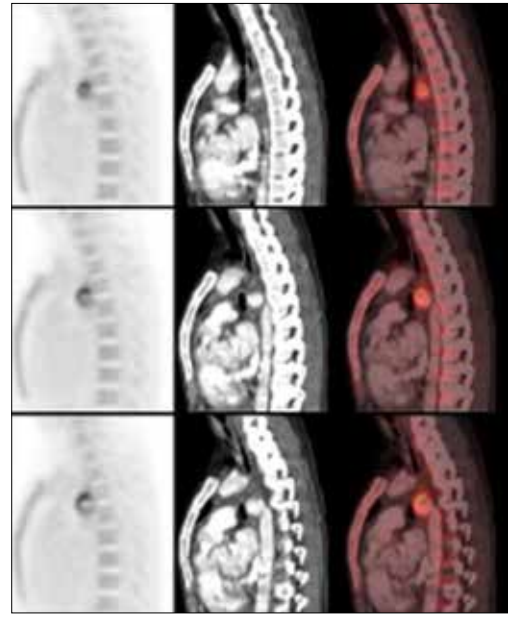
18 FDG PET-CT revealed increased intensive glucose uptake on dilated aortic segment adjacent to distal coarctation zone.
